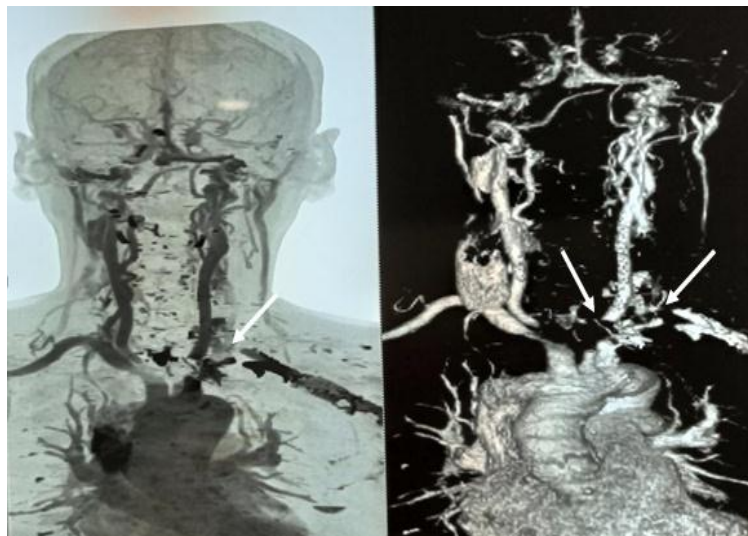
CT angiography of the supra aortic trunks of the patient.
